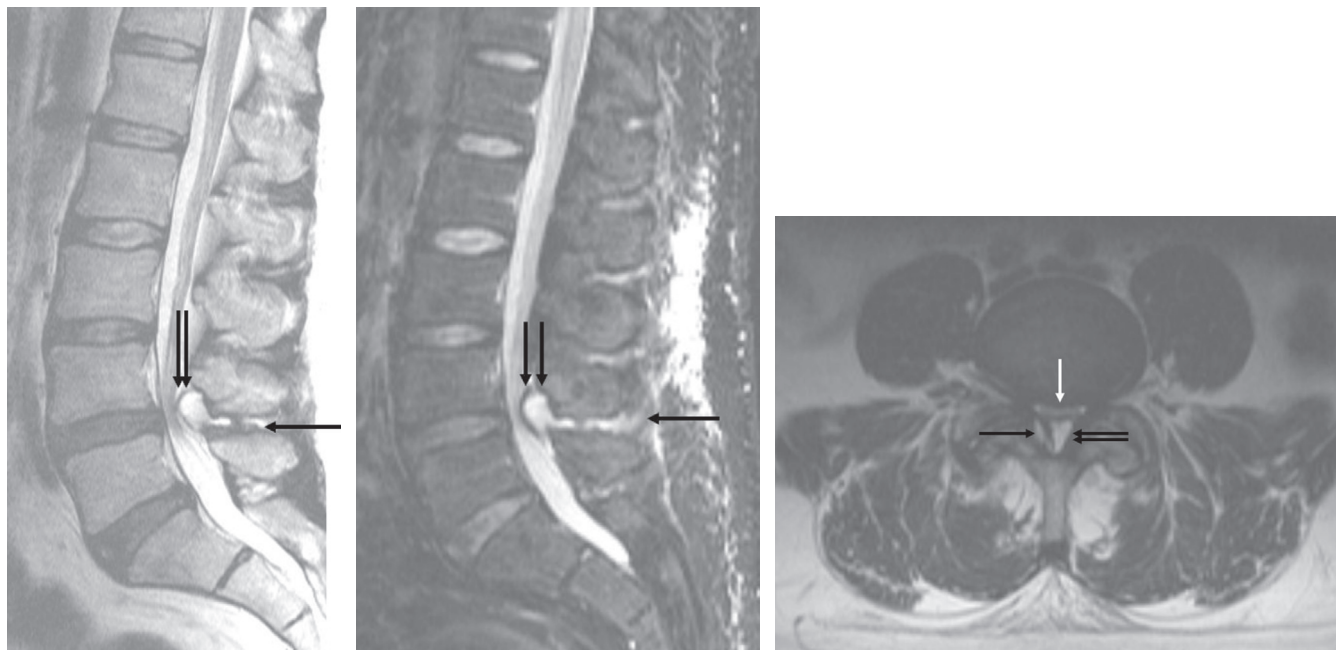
Midline sagittal T2-weighted (Left) and short tau inversion recovery (Middle) magnetic resonance images show hyperintense signal between the L4 and L5 spinous processes, consistent with interspinous bursa formation (arrow). Note the posterior epidural cyst in clear continuity with the interspinous bursa (double arrow). Axial T2-weighted image (Right) demonstrates severe compression of the thecal sac (white arrow) by the posterior epidural cyst (double arrow). Also seen is a synovial cyst arising from the right facet joint (single black arrow).
